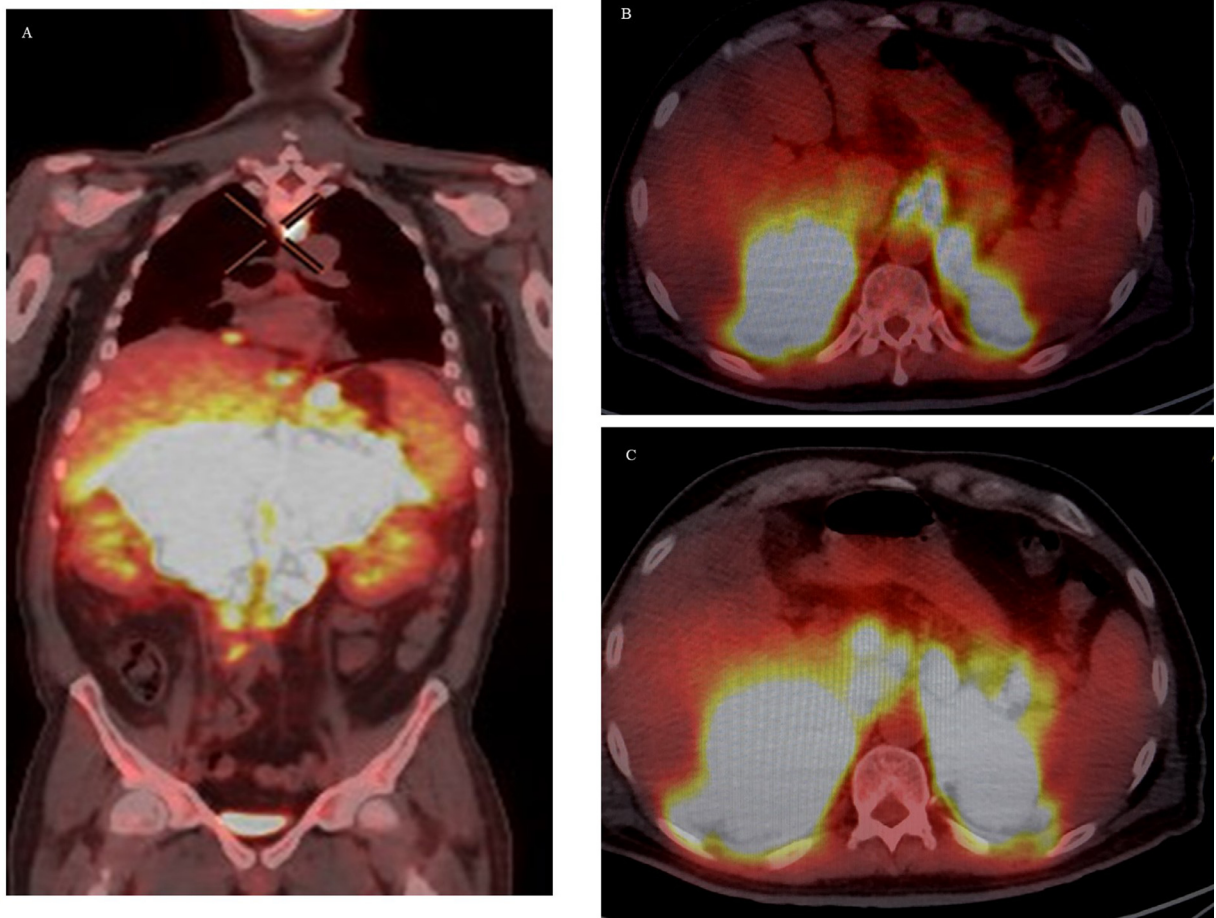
Positron emission tomography/computed tomography (PET/CT) coronal and axial views showing intensely hypermetabolic disease within the abdomen, involving both the adrenal glands 3 weeks after admission at the hospital.
